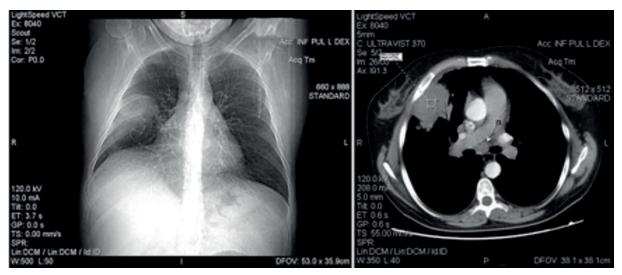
Chest X-ray: Homogenous shadow in the right middle lobe; CT: lobular expansive infiltration located within the right middle lobe
